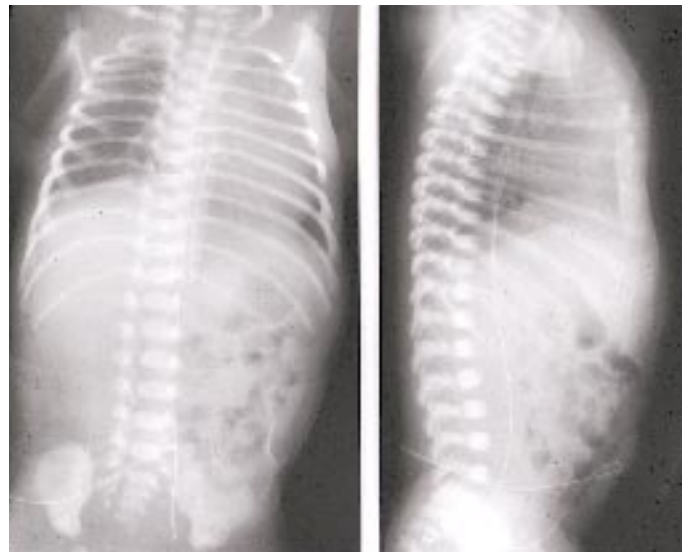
Chest and abdominal radiograph of an infant after placement of an umbilical venous catheter. Note the placement of the catheter in the liver with air outlining the portal venous system.
